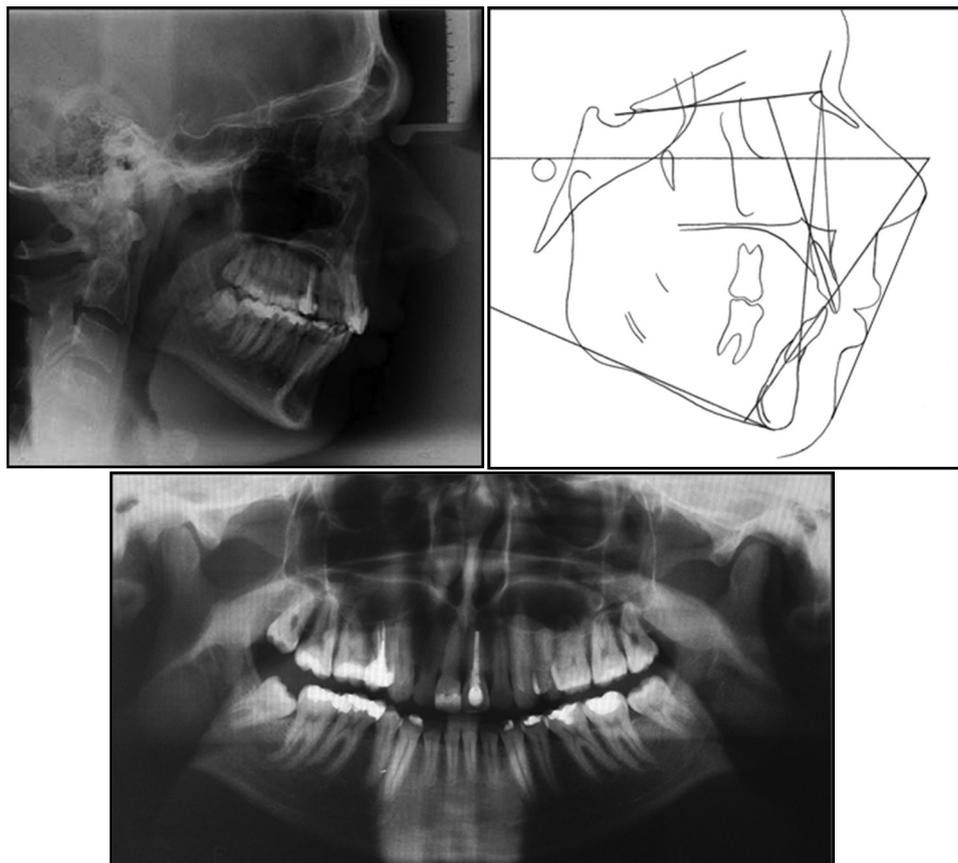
Final radiographs and cephalometric tracing.
